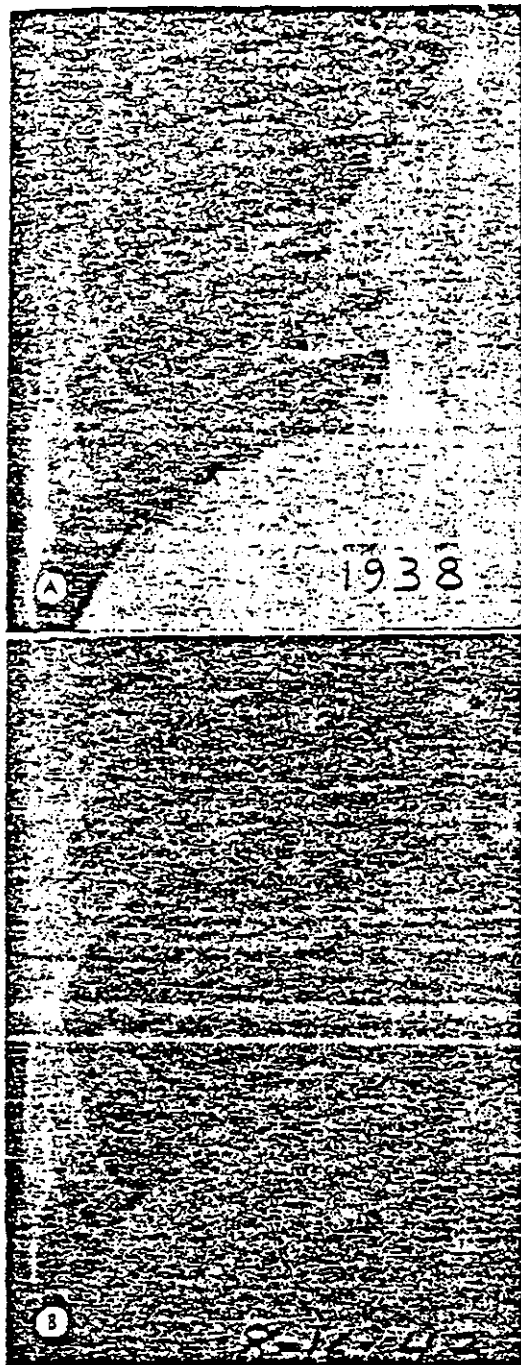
(A) This worker is forty-one years of age. The roentgen findings are essentially negative. He has worked for ten years as a weaver. (B) Well advanced asbestosis in the same individual at forty-six years of age. He has now been a weaver for fifteen years. Note the marked changes in the right lower lobe and the difference in the roentgenographic appearance as compared to that observed five years previously. The changes in this individual are more prominent on the right side. The right dome of the diaphragm is elevated.
